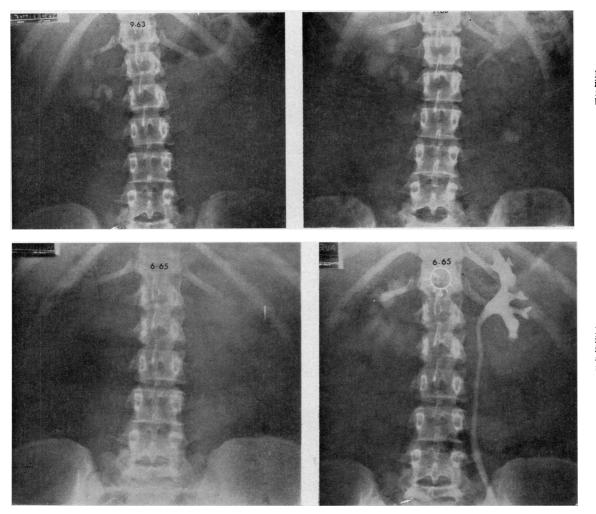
Plain abdominal radiograph and intravenous pyelogram before treatment with D-penicillamine.
